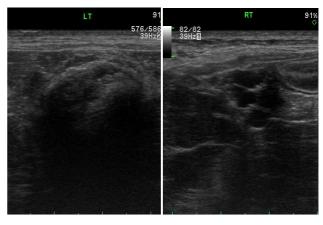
The ultrasonographic images of the left and right ovary. The left ovary (LT) was seen as a enlarged, hyperechogenic parenchyma and distal acoustic shadow. The right ovary (RT) was observed normal structure with small ovarian cysts.
